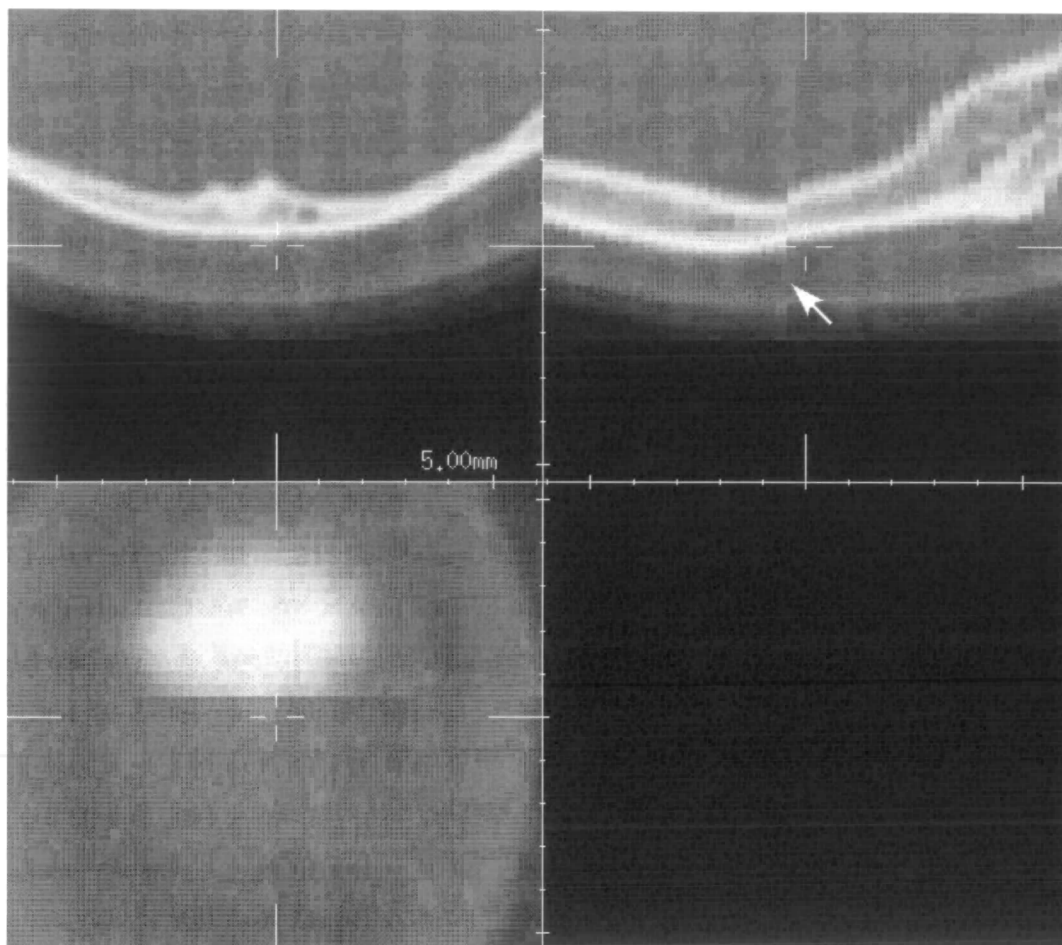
Example slices through the CT images of patient W showing movement during an acquisition.
